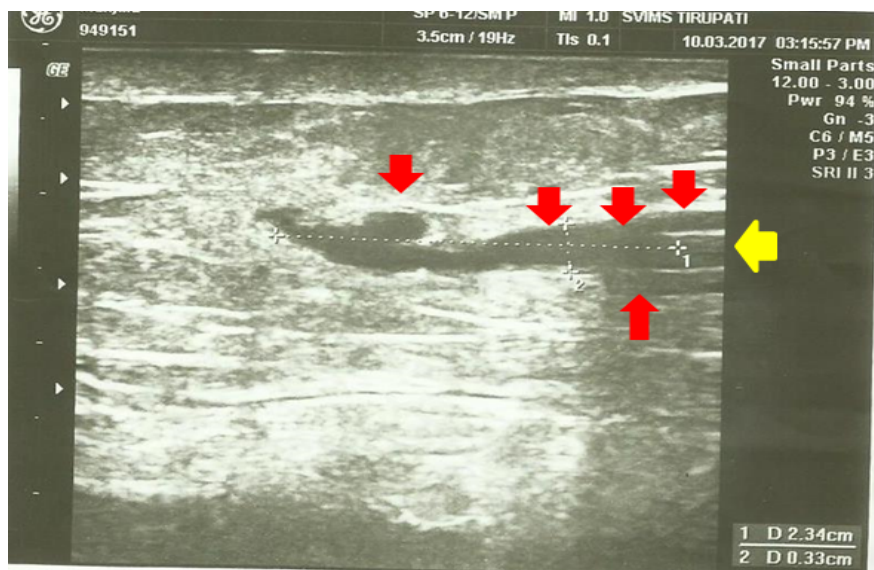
Ultrasound of Tunnel.
